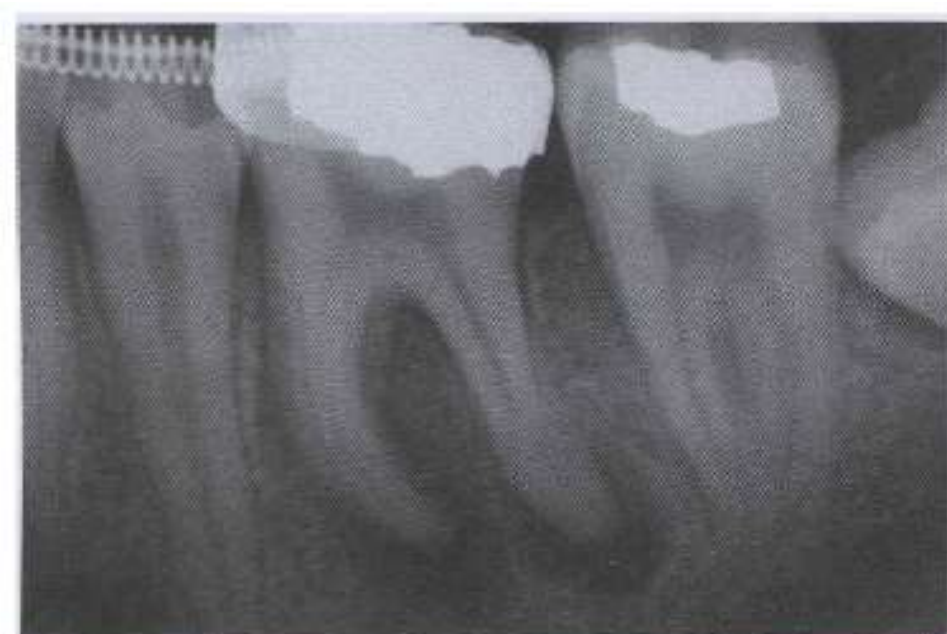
• Periapical granulomas. Discrete periapical radiolucencies associated with the apices of the mandibular first molar. (Courtesy of Dr. Garth Bobrowski.)
